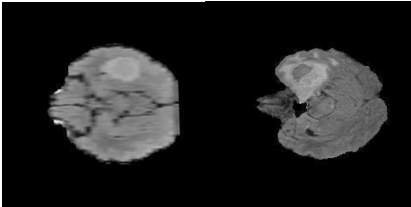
T2-Flair MRI image for a)LGG and b)HGG
